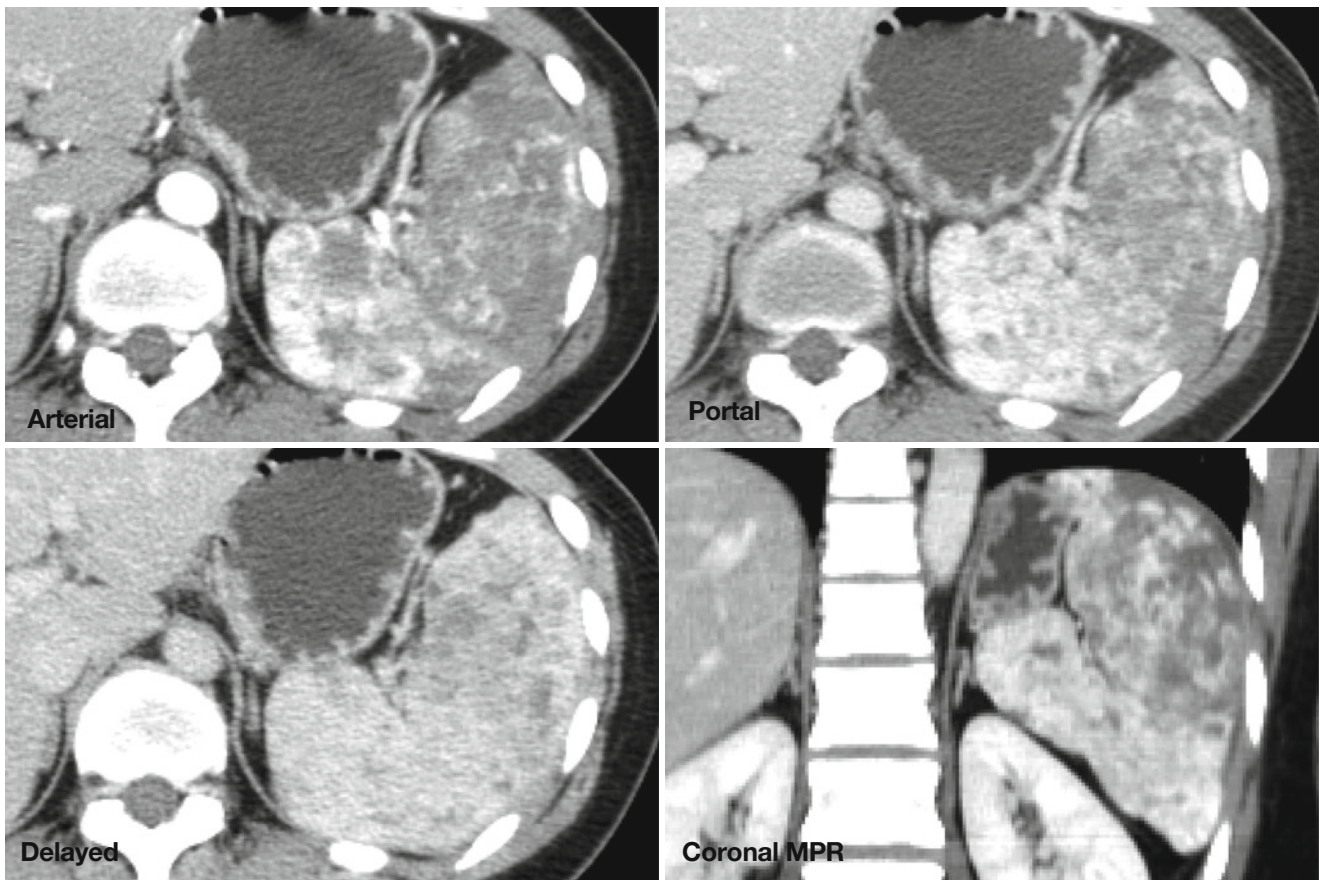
Splenic angiosarcoma in a 33-year-old female. Dynamic contrast-enhanced transverse CT images demonstrate a heterogeneously enhancing mass-like lesion replacing nearly whole portion of the enlarged spleen
